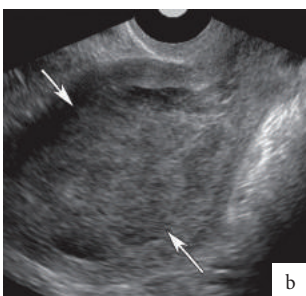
Sagittal endovaginal ultrasound showing a mass in the endometrial cavity of the uterus (arrows). c. Sagittal T2-weighted MR scan depicting a large mass (arrowheads) extending from the uterine cavity into the cervix and vagina (arrow).
